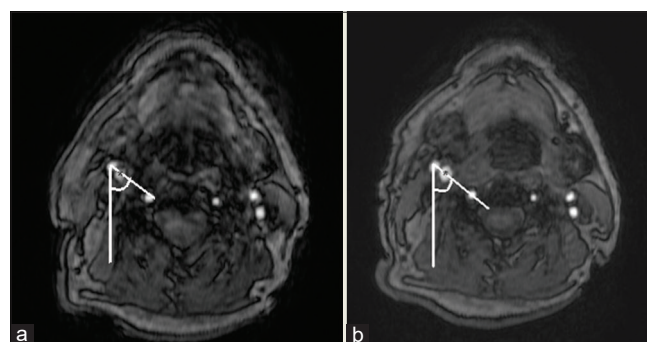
Twisted angle measured on magnetic resonance angiography in the same manner as that on computed tomography angiography before (a) and after (b) carotid endarterectomy.
